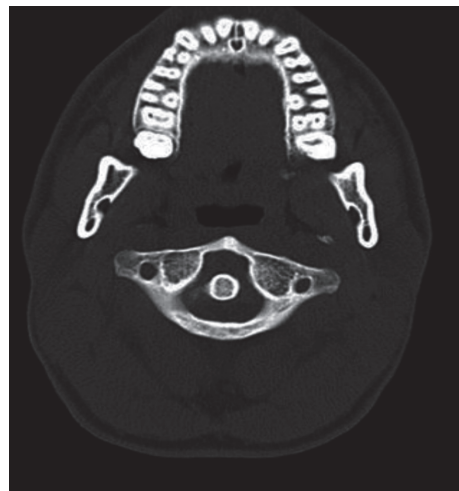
CT Scan Cervical Spine Revealing Evidence of C1-C2 Subluxation with Increased Anterior Dens Interval
